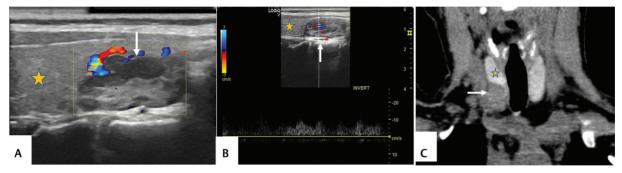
(A and B) USG neck sagittal plain with color and spectral Doppler shows heterogeneously hypoechoic lesion (arrow) with vascularity adjacent to the lower pole of right lobe of thyroid (asterisk). (C) Plain CT neck coronal section shows hypodense lesion (arrow) at lower pole of thyroid (asterisk), suggesting parathyroid neoplasm.
